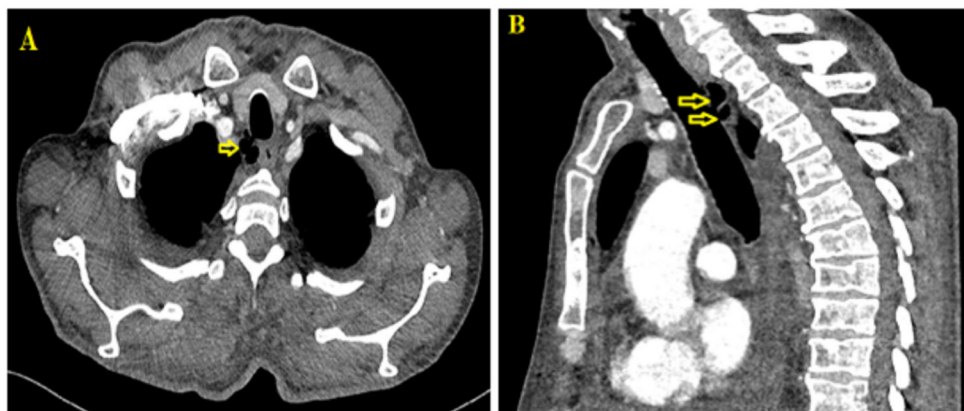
CT image of tracheal diverticulum in the axial (A) and saggital (B) planes, located in the right osterolateral part of the trachea
